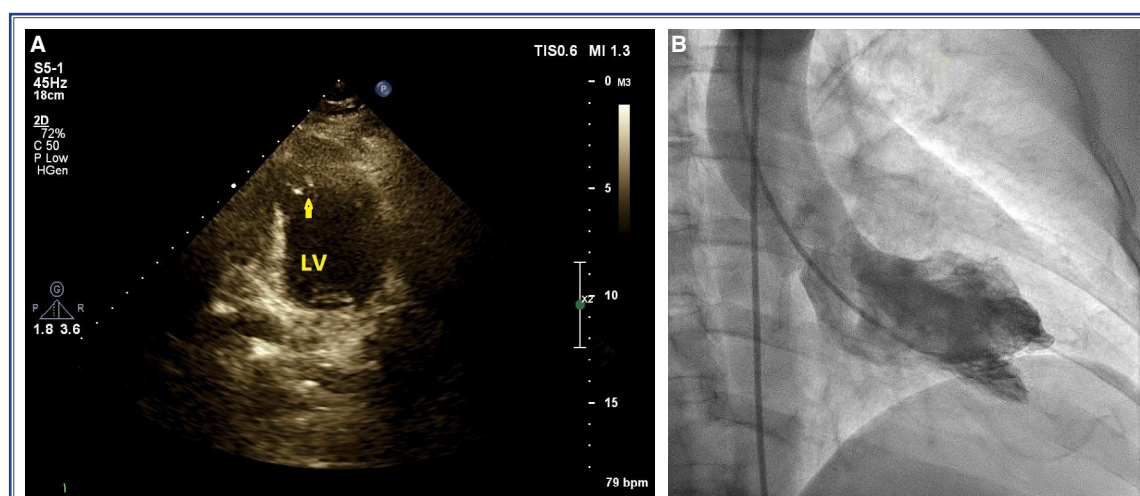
(A) Dividing bundle in the left ventricular apex constituting a chamber between the left and right ventricles and resulting in a bifid cardiac apex as observed on transthoracic echocardiography. (B) Left ventriculography confirming the bifid cardiac apex.
